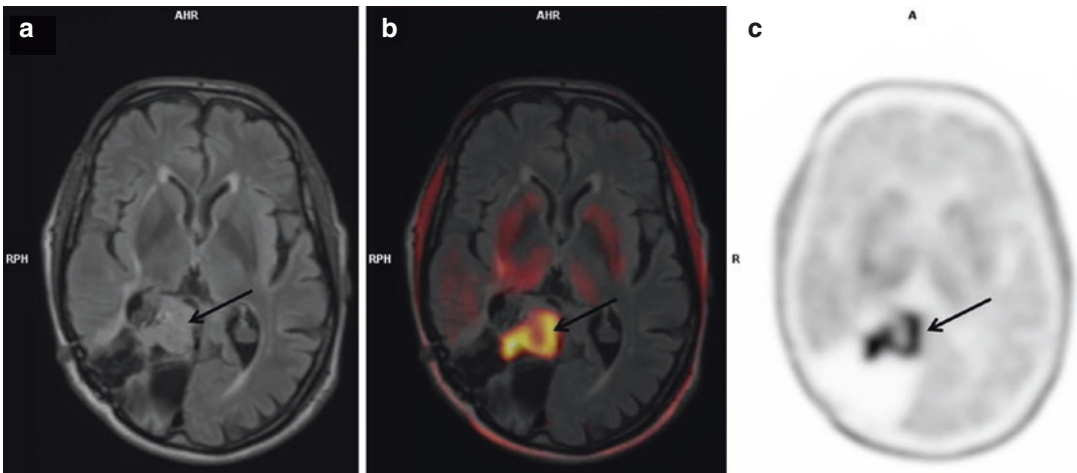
Axial MRI (a), fused ^{18}F -FET PET/MRI (b) and ^{18}F -FET PET (c) images in a 64 y.o. female patient treated with surgery and radiochemotherapy for a right temporal-occipital high-grade glioma and with a contrast-enhanced
